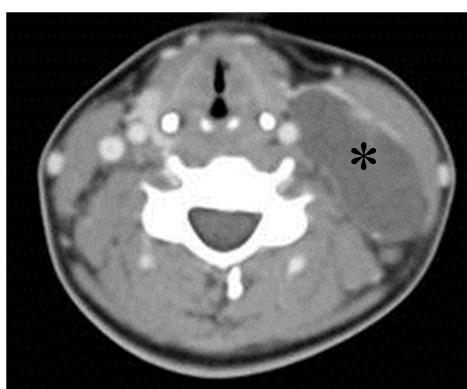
Axial computed tomography scan showing multilocular, thin wall-enhancing hypodense lesion (asterix) located deep to the left sternocleidomastoid muscle and posterior to the left submandibular gland. The lesion insinuates in between the left carotid artery and internal jugular vein.
